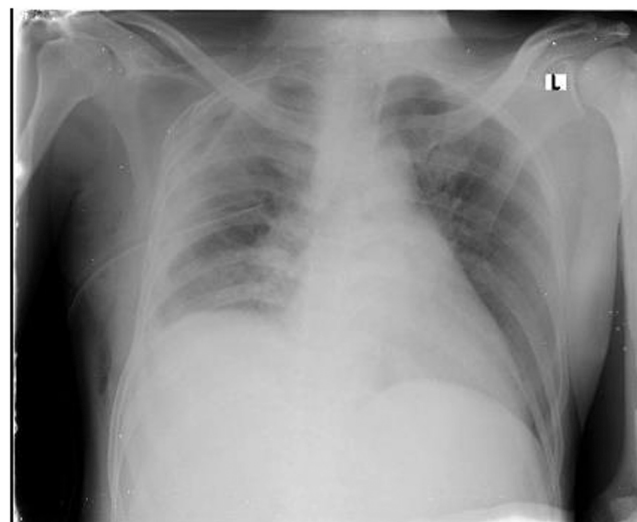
Chest X-ray showed right chest tube, resolution of empyema, with subsequent small right apical pneumothorax.
